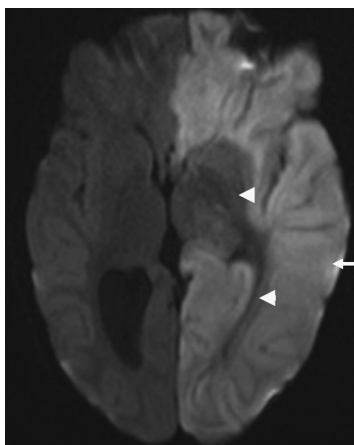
Prolonged seizure and status epilepticus. This b1000 DWI sequence shows left hemispheric cortical thickening and hyperintensity (*arrow*), sparing the white matter and deep gray nuclei (*arrowhead*) in this 3-year-old patient. Note the multiple vascular territories involved, making infarct less likely.
